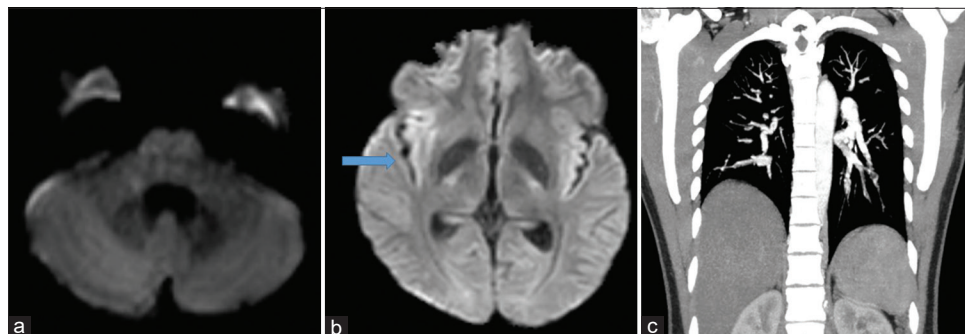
MRI DWI sequences. Picture on the left showing resolution of pontine DWI lesions. Picture on the right shows a right insular DWI hyperintensity. Panel on the extreme right, CTPA; shows normal pulmonary vasculature
